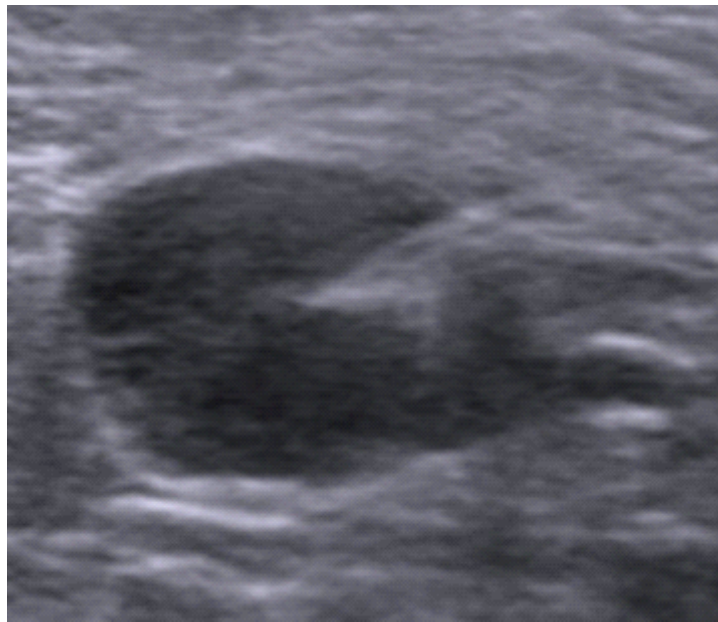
Pre-operative localization with tattoo ink: 67-year-old female with right breast cancer and biopsy proven metastasis to a right axillary lymph node. Ultrasound image demonstrates ultrasound-guided injection of Spot tattoo ink into the cortex of the previously biopsied lymph node. The tattooed lymph node was visually identified as a black lymph node intra-operatively, and surgical pathology confirmed metastatic carcinoma involving the lymph node with biopsy site changes. However, the tattooed node was not a sentinel node. The patient also underwent sentinel lymph node biopsy which yielded 0/1 positive lymph nodes.
